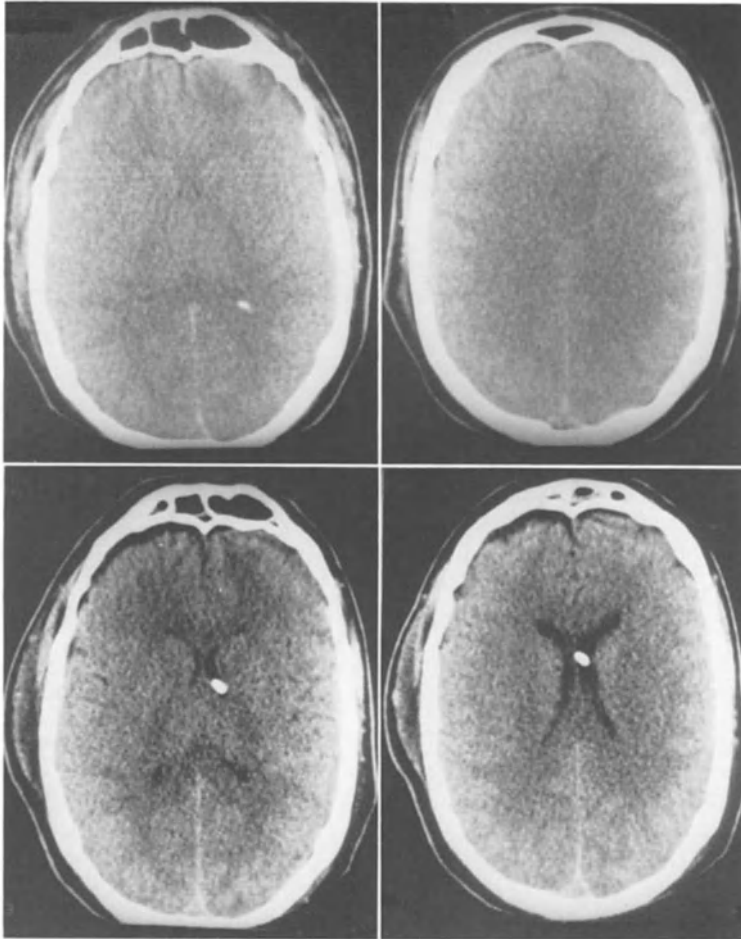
This young adult injured in a traffic accident scored 7 points when admitted to a local hospital. The admission CT scan showed generalized brain swelling (upper part). ICP ranged between 25 and 35 mmHg. Six days after trauma ICP was normal and the next CT scan (lower part) showed normal ventricles and cisterns with discrete frontal hygromas which disappeared on a later CT scan
